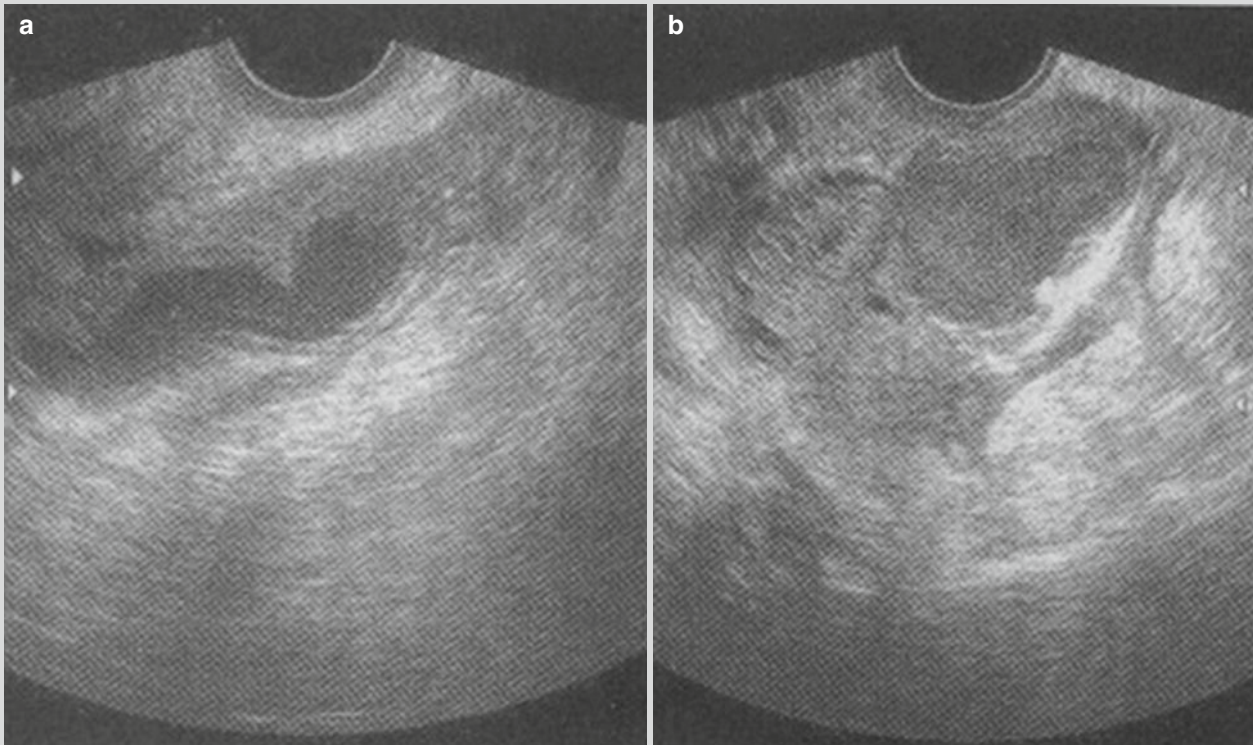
Pyosalpinx. (a, b) Pyosalpinx by ultrasound
